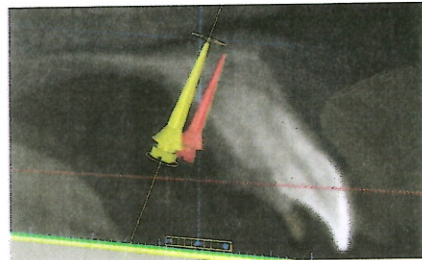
STL files showing an inserted miniscrew on the sagittal plane of the cone-beam computed tomography (CBCT) scan passing through the ideal insertion point.
